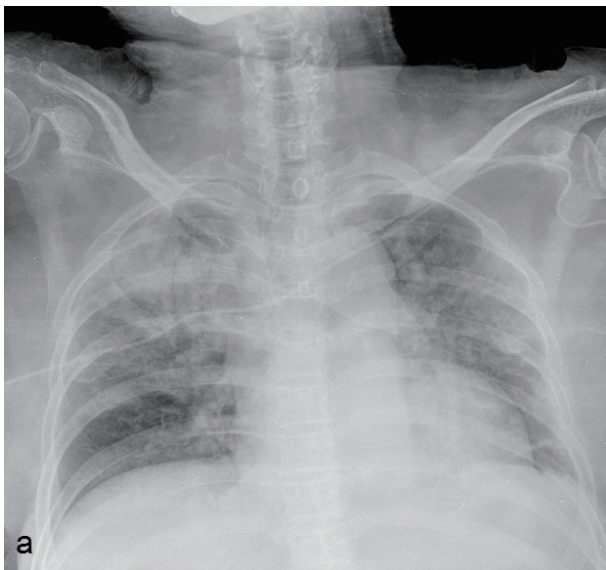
a. Chest radiography upon admission showing bilateral pulmonary infiltrations. b. Progressive pneumonitis with a right-sided tension pneumothorax
